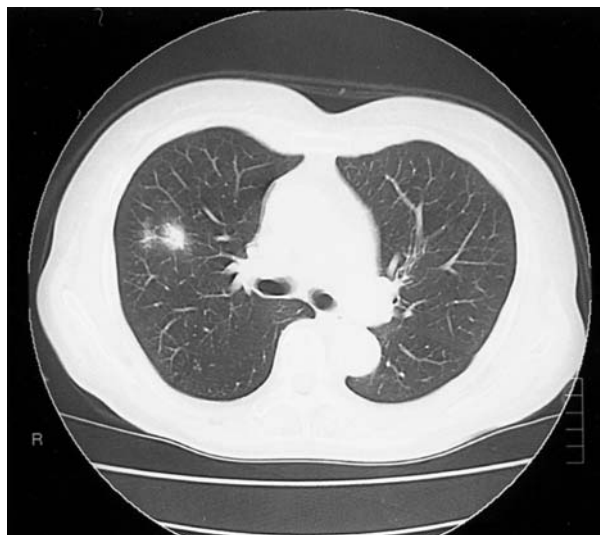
Computed tomography taken on the same day shows small nodular shadow in the right upper lobe
